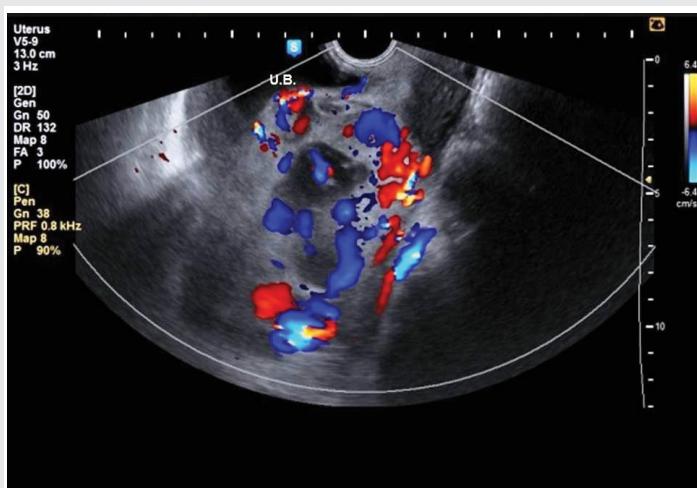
Trans-vaginal 3D ultrasound Doppler showing placental vasculature invading the whole myometrium and reaching the urinary bladder anteriorly.
